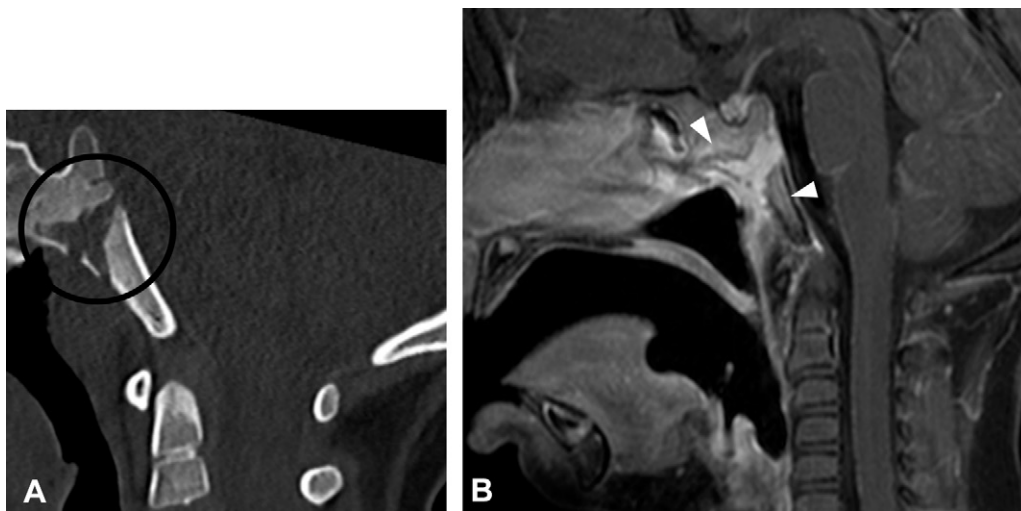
Spheno-occipital synchondrosis-related osteomyelitis diagnosed in a 3-year-old boy who presented with neck pain after adenoidectomy. (A) Sagittal CT image shows widening and irregularity of the spheno-occipital synchondrosis, with subtle marginal sclerosis (circle outline). (B) Sagittal contrast-enhanced T1W FS MR image shows enhancement in and widening of the synchondrosis and adjacent enhancement of the sphenoid body and basiocciput (arrowheads).
